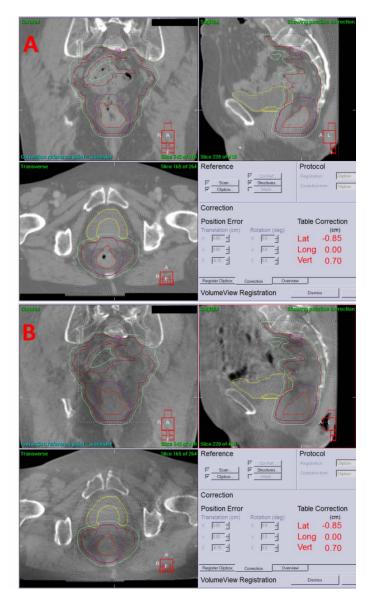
Planning CT and Figure 5b. CBCT, demonstrating an example of a treatment plan with a superior nodal volume (GTVn) requiring consideration for potential differential motion.
